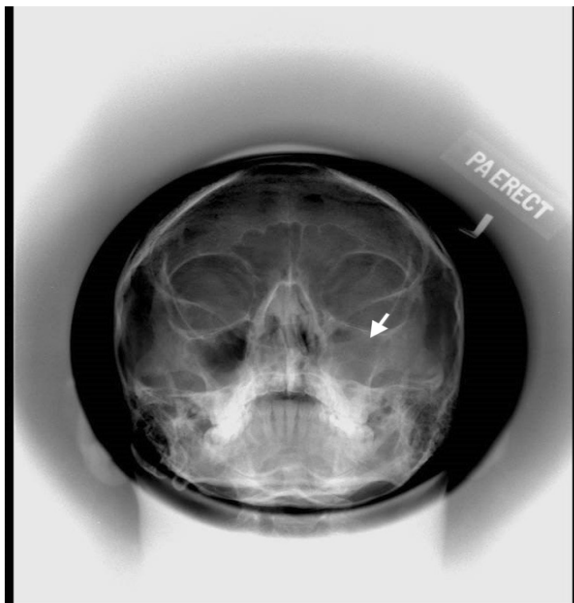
Sinus X-ray showing opacification of the left maxillary sinus with air fluid level (white arrow).
